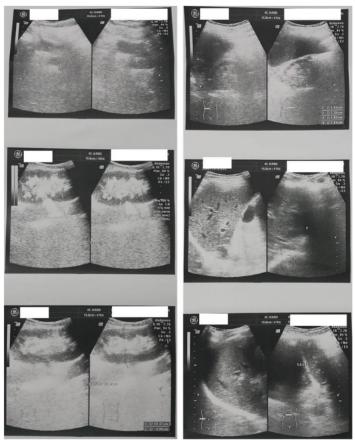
Abdominal ultrasound: right and left kidney appeared smaller, there was no apparent abnormality in the kidney in the lower right abdomen. Other organs had no abnormalities.
